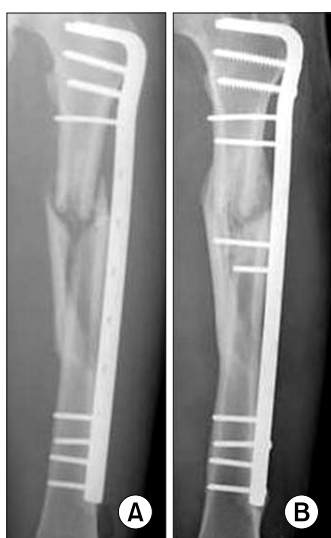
Preoperative and postoperative X-ray of one nonunion patient. The postoperative X-ray shows that a callus had formed and union was achieved.
